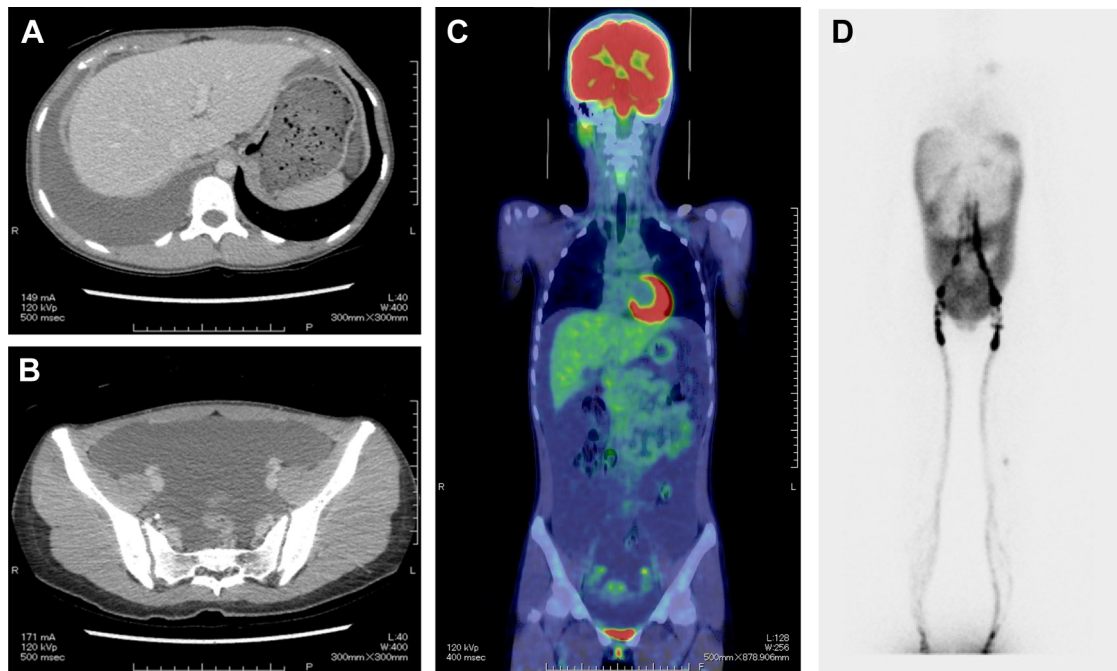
A, Transverse computed tomography (CT) view demonstrating ascites in the abdominal cavity. B, Transverse CT view demonstrating ascites in the pelvic cavity. C, Positron emission tomography-CT. D, Lymphoscintigraphy demonstrating the leakage of chyle in the peritoneal cavity 90 minutes after bipedal injection of technetium Tc 99m-labeled human serum albumin.
